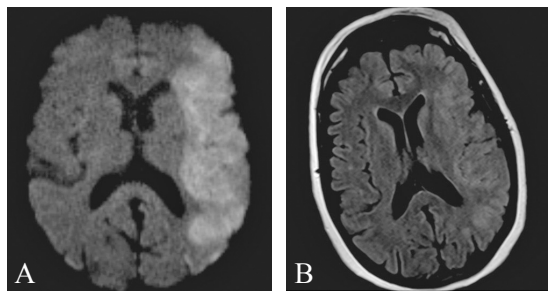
Brain MR images in a patient with COVID-19 and an acute ischemic stroke in the territory of left medium cerebral artery: A) DWI-weighted sequence; B) FLAIR-weighted sequence.
